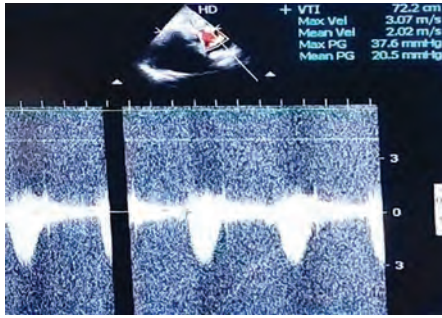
Postoperative echocardiography showing pulmonary valve (mean PG 20.5 mm Hg)
